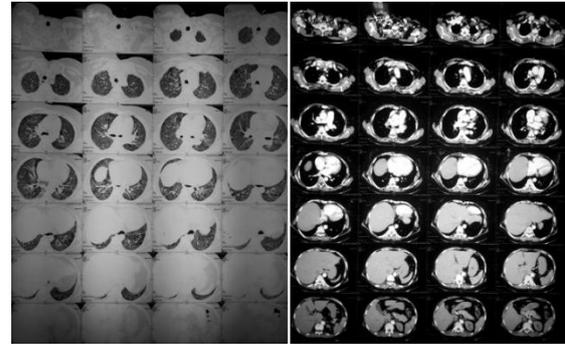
High resolution computed tomography of the patient.
